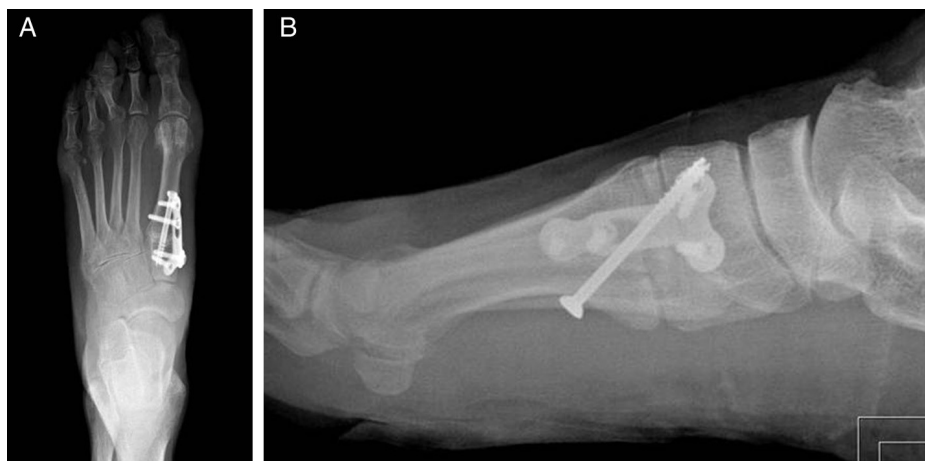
(A) Anteroposterior radiograph showing excellent reduction of the first intermetatarsal angle with all hardware in good position. (B) Lateral view demonstrating placement of the plantar interfragmentary screw and plate fixation.
